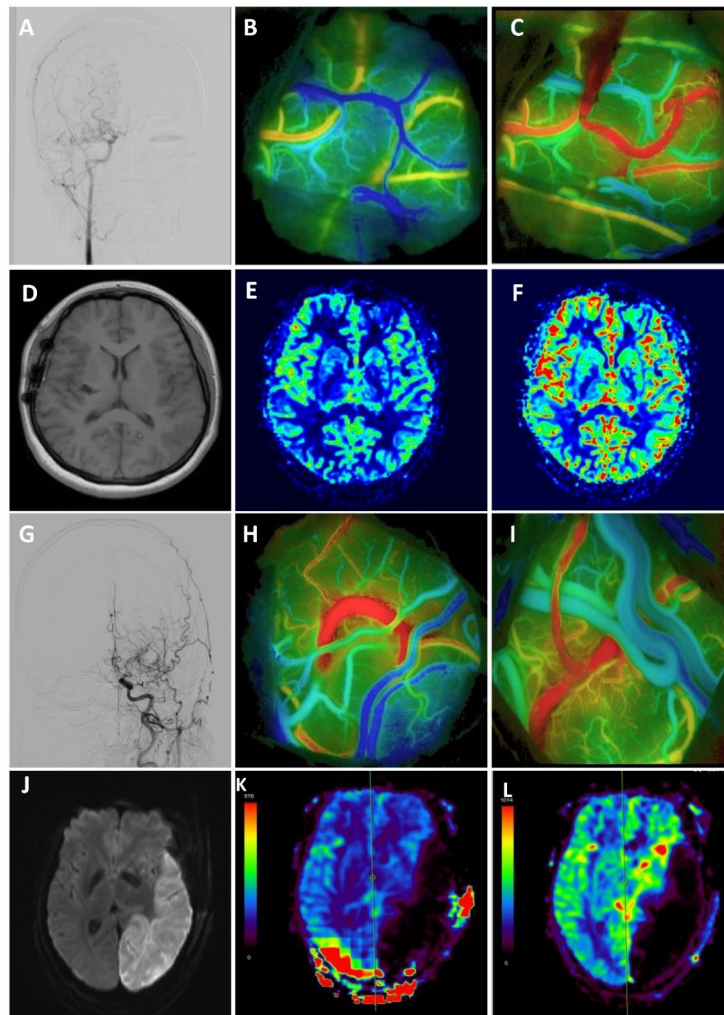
Representative hyperfusion syndrome and cerebral infarction cases. The 21-year-old female presented HPS after bypass surgery, the patient experienced speech disorder on the 6rd day after surgery and no cerebral infarction detected on magnetic resonance imaging. (A-F). A Coronal position of digital subtraction angiography image. B pre-bypass color maps of FLOW800. C post-bypass color maps of FLOW800. D axial position of T1 imaging. E Cerebral blood flow in perfusion weighted imaging. F Cerebral blood volume in perfusion weighted imaging. The 32-year-old male presented cerebral infarction after bypass surgery, the patient experienced movement disorder, speech disorder and visual impairment on the 3rd day and magnetic resonance imaging revealed severe cerebral infarction in the left side (G-L). G Coronal position of digital subtraction angiography Image. H pre-bypass color maps of FLOW800. I post-bypass color maps of FLOW800. J Axial position of diffusion weighted imaging. K Cerebral blood flow in perfusion weighted imaging. L Cerebral blood volume in perfusion weighted imaging.
